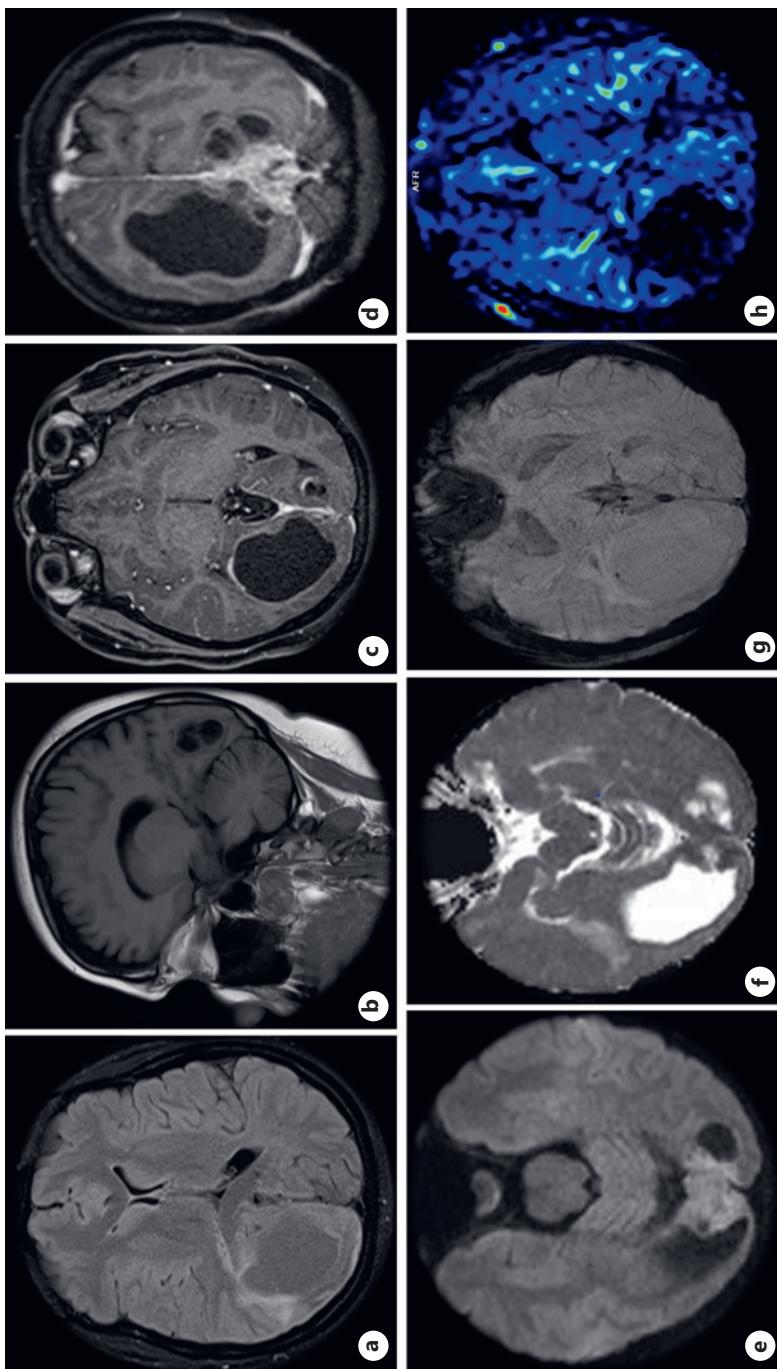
Solid-cystic lesion with epicenter in the right occipital lobe (a, b) and heterogeneously enhancing solid component adjacent to the torcula (c, d), showing mild restricted diffusion (e, f), delineating a central area of necrosis. No associated hemorrhagic or calcified component (g) or increased perfusion (h). Sequences: axial FLAIR (a), sagittal T1 (b), axial and coronal T1 post-contrast (c, d), axial DWI and ADC map (e, f), axial ASL (g), and axial SWI (h). ASL, arterial spin labeling; FLAIR, fluid-attenuated inversion recovery.
